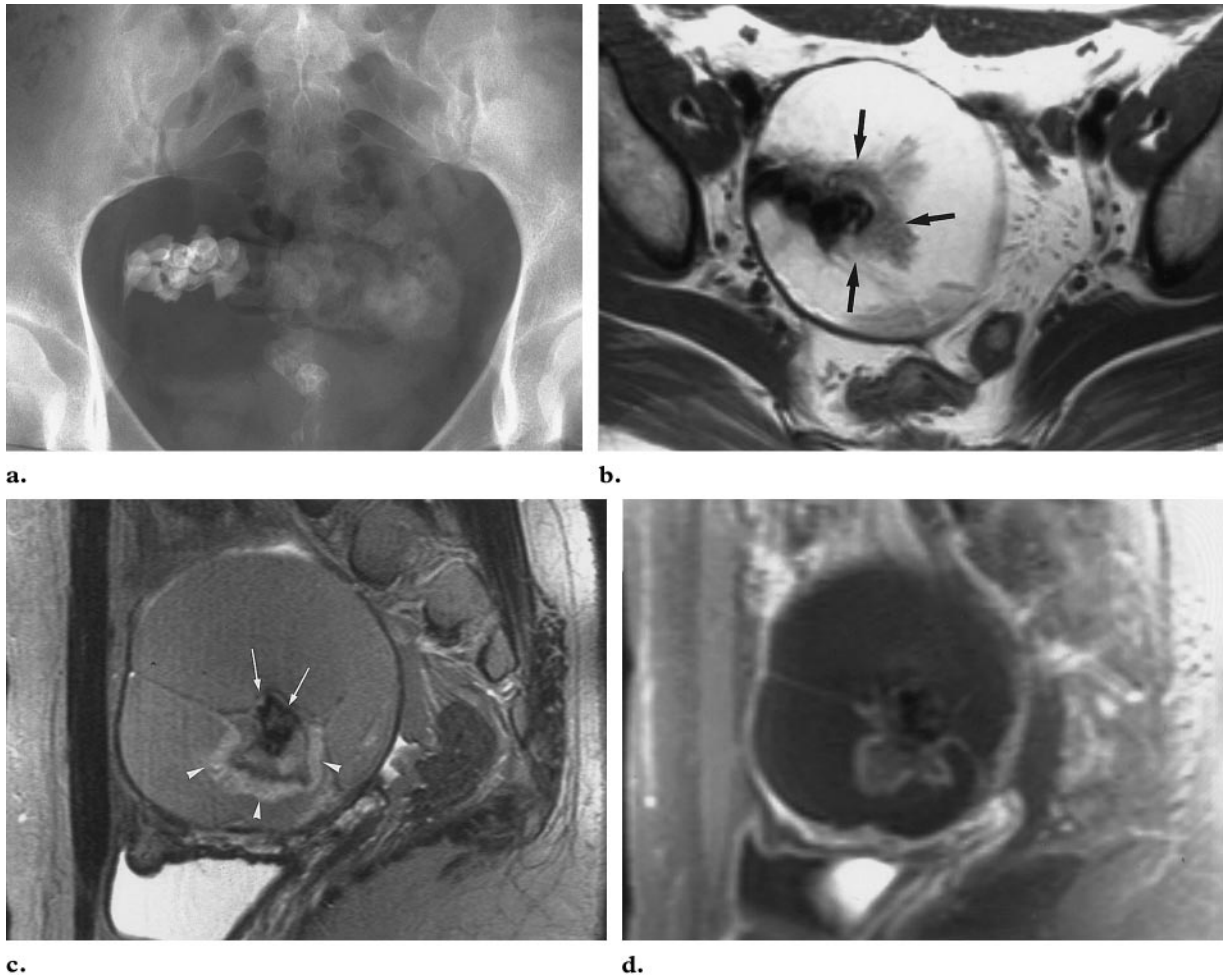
Mature teratoma in a 21-year-old woman. (a) Conventional radiograph shows a large mass with fat opacity and multiple toothlike calcifications, findings that indicate a typical mature teratoma. (b) Axial turbo spin-echo T1-weighted MR image (800/12) shows a well-defined round, hyperintense mass with hypointense calcifications and a mural nodule (arrows). (c) On a sagittal turbo spin-echo T2-weighted MR image (3,800/99), the tumor is isointense relative to subcutaneous fat. The calcifications have low signal intensity (arrows), whereas the Rokitansky protuberance has high signal intensity (arrowheads). (d) Gadolinium-enhanced fat-suppressed FLASH T1-weighted MR image (147/4.8) demonstrates the mass with markedly decreased signal intensity compared with the non-fat-suppressed T1-weighted image (cf b).
